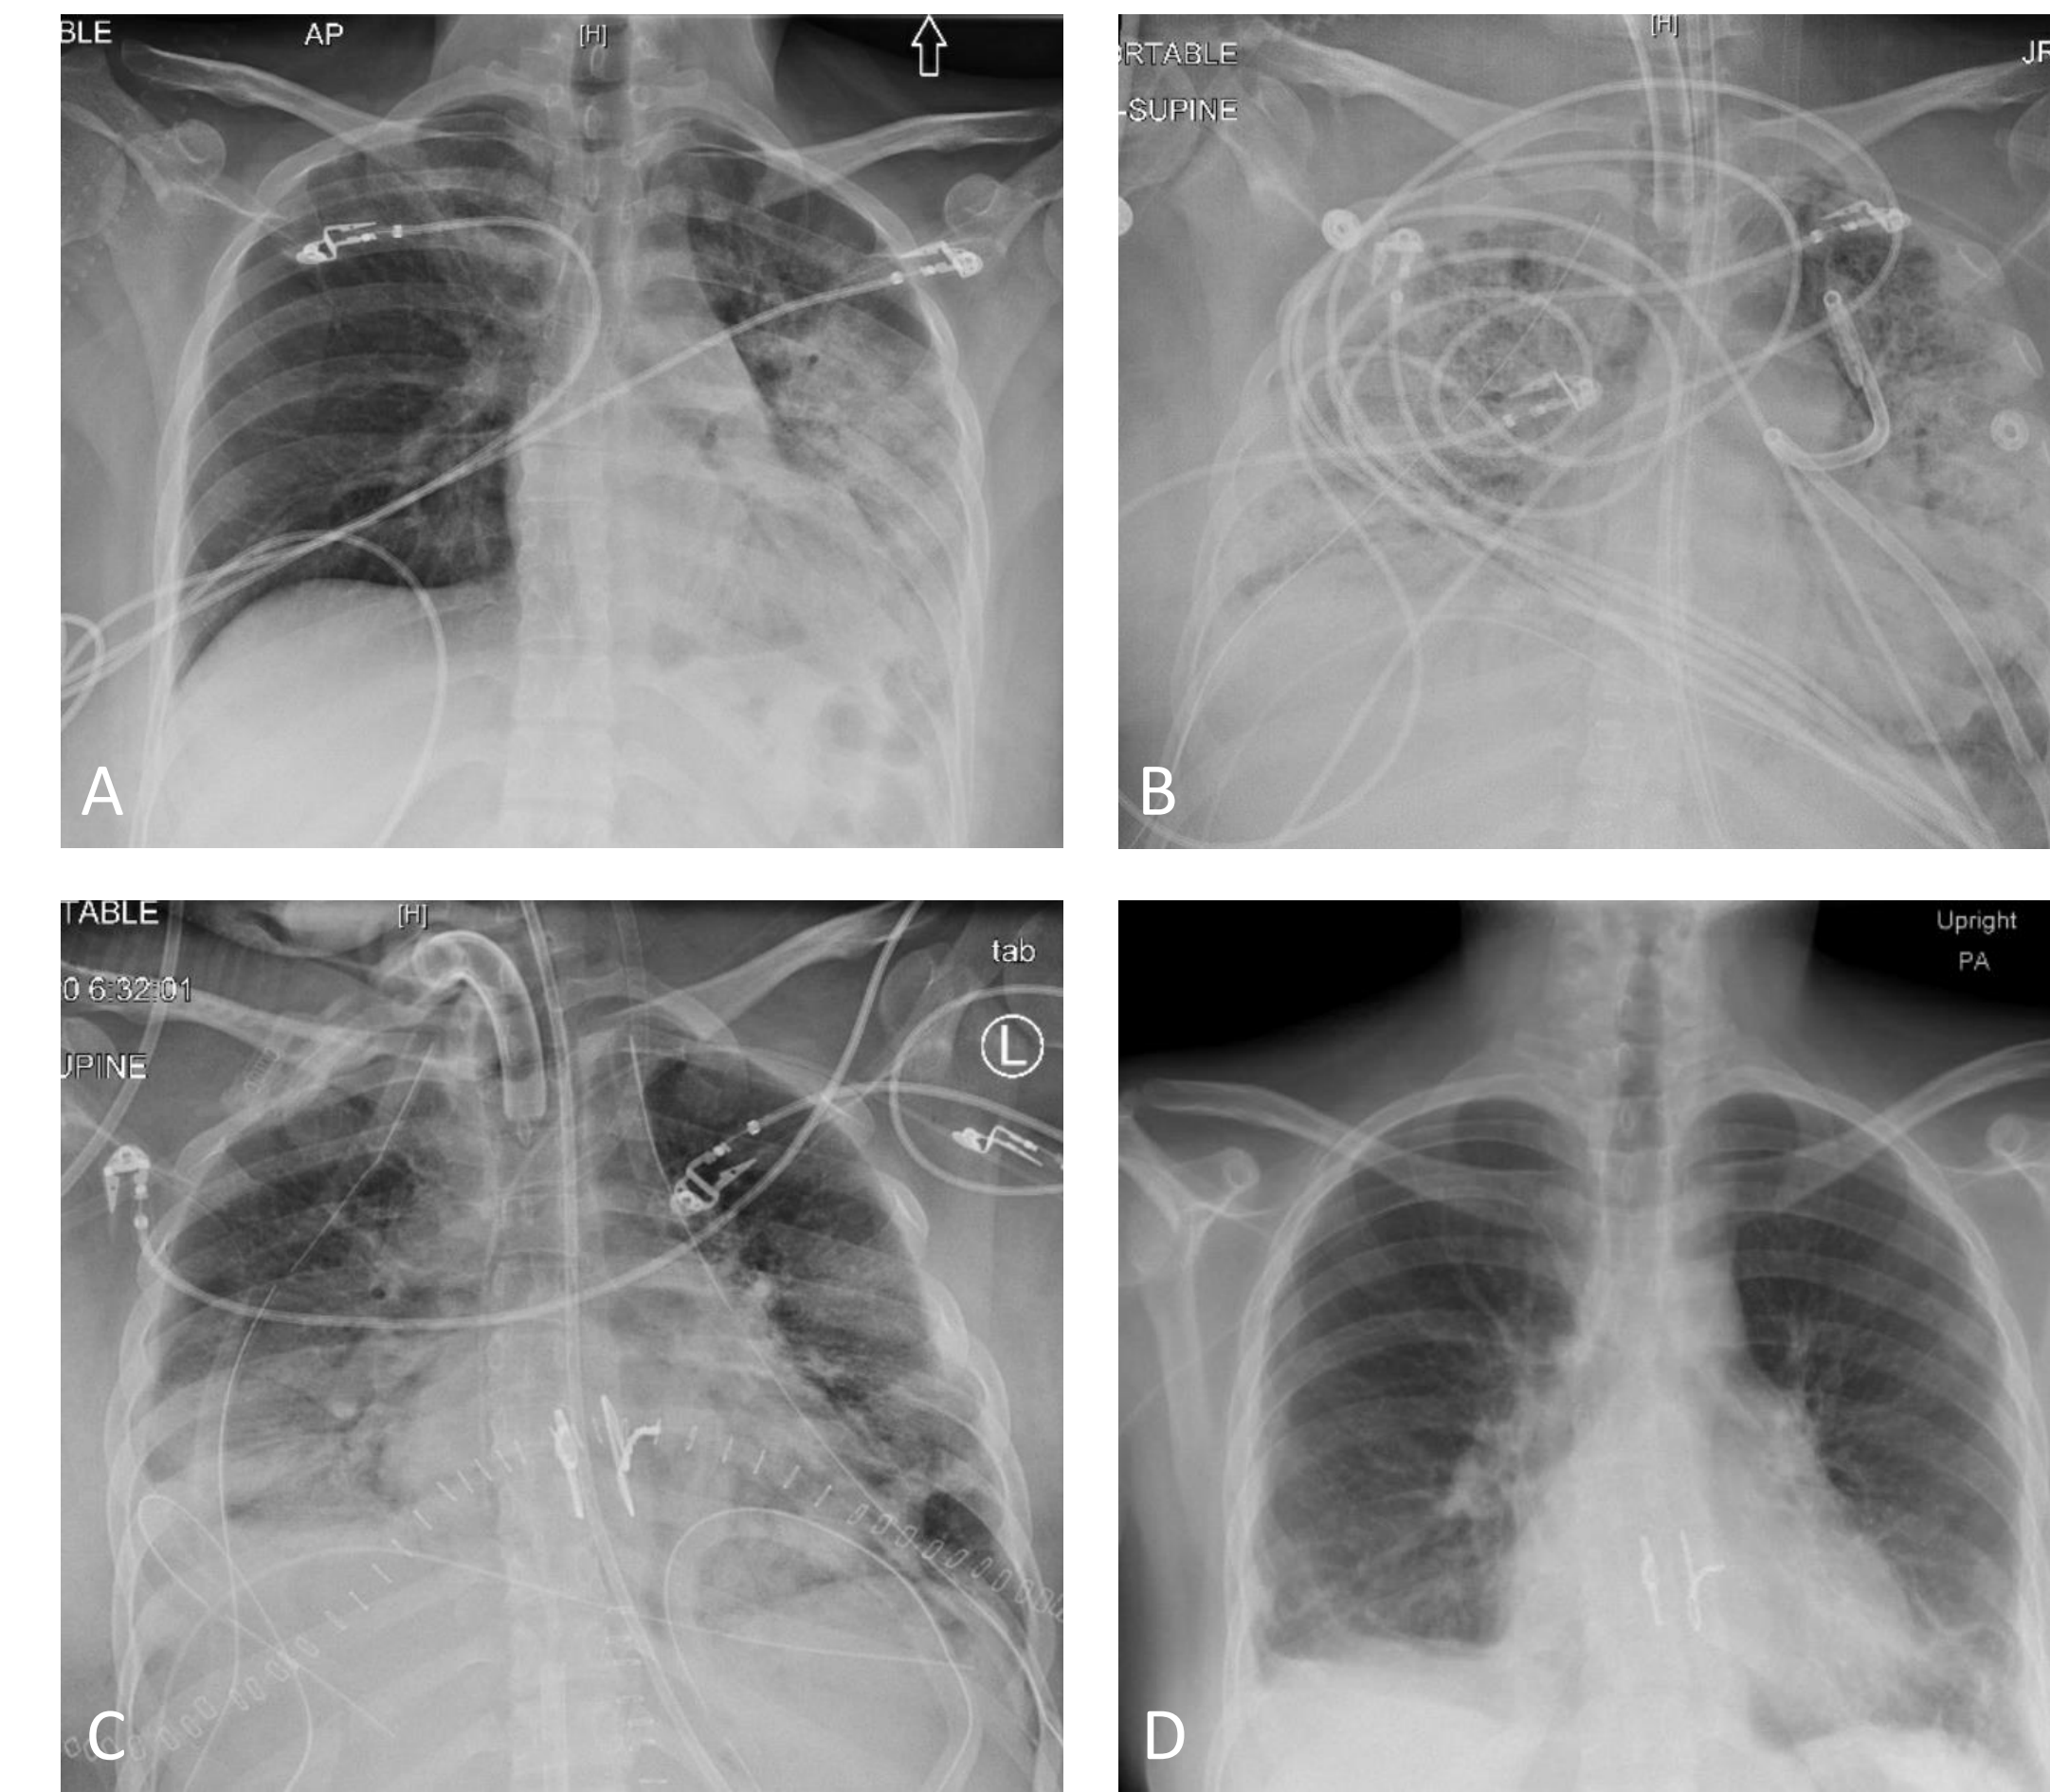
A) Initial chest x-ray (CXR) on 4/26; B) pre-transplant CXR on 6/5; C) post-transplant CXR on 6/6; D) surveillance CXR from AIR on 7/27.
